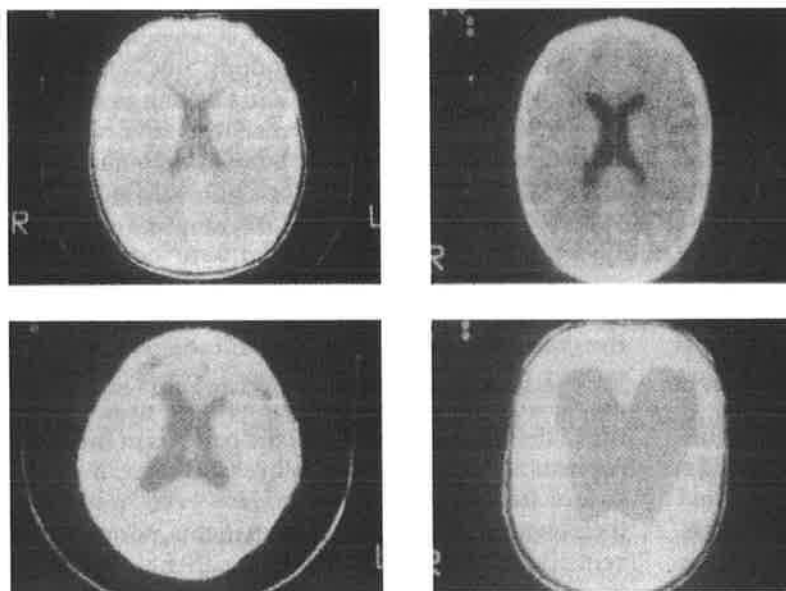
Ventricular patterns found on computed tomographic scan in Crouzon's syndrome: (top left) normal, (top right) mild ventriculomegaly, (bottom left) moderate ventriculomegaly, (bottom right) severe ventriculomegaly.
